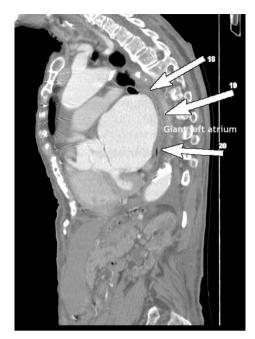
Computed tomography image with contrast demonstrating giant left atrium and apical hypertrophic cardiomyopathy.
